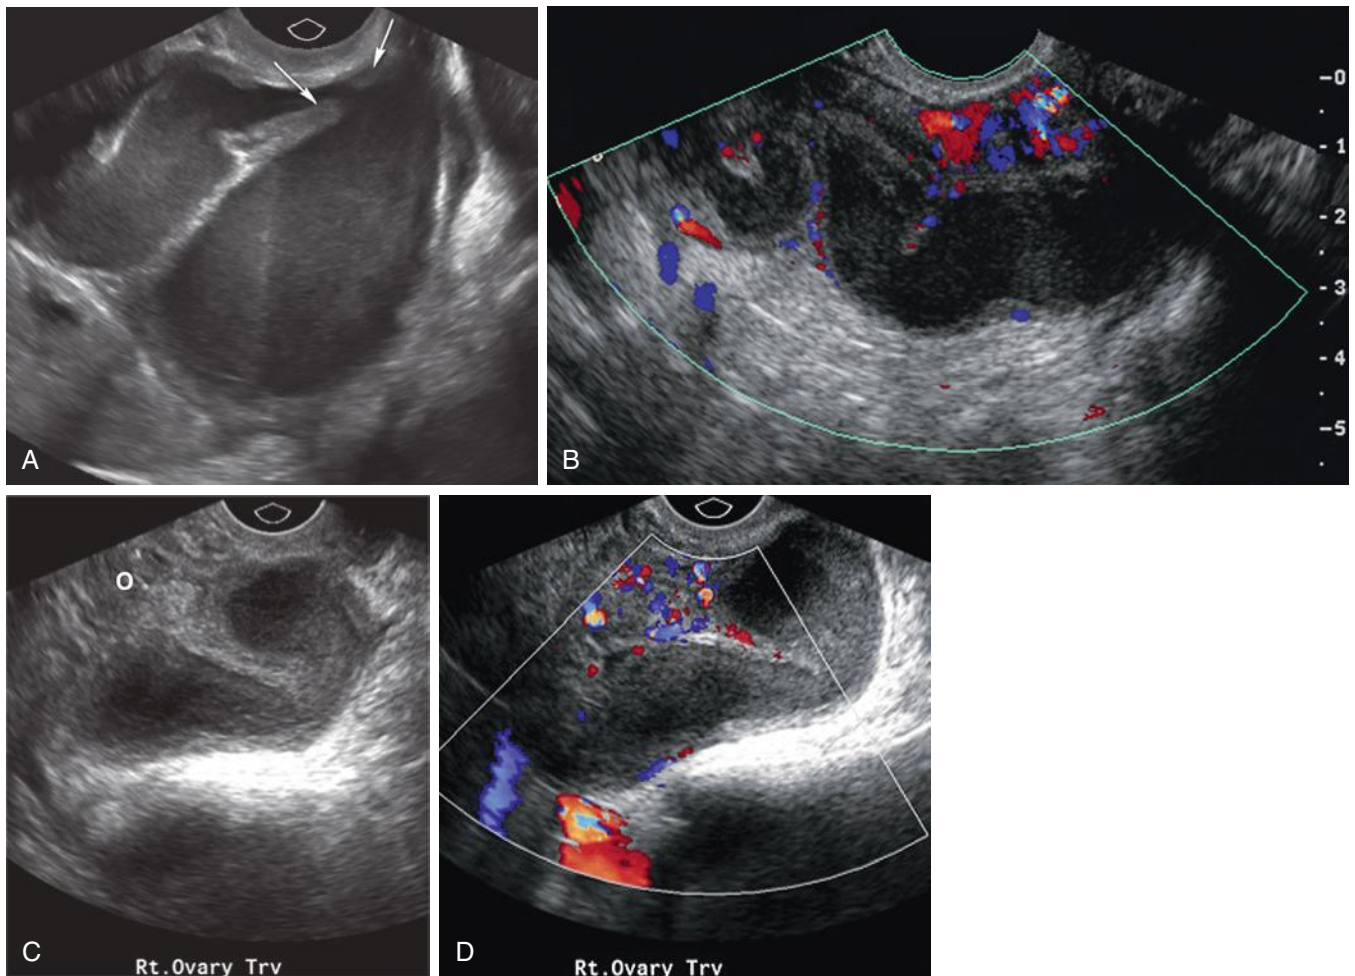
Pyosalpinx. A, The left fallopian tube in a patient with pyosalpinx is markedly dilated and filled with echogenic material, consistent with pus, hemorrhage, or debris. Note fluid/fluid level and thick echogenic wall. The tube is curled back upon itself demonstrating the incomplete septation sign and is also focally symmetrically indented, the "waist sign" (*arrows*). B, Color Doppler image of the left adnexa in a second patient with pyosalpinx demonstrating a dilated serpiginous tubular structure containing low level intraluminal echoes and increased mural vascularity. Gray-scale (C) and color Doppler (D) ultrasound images from a third patient with pyosalpinx demonstrating a dilated fallopian tube adherent to the enlarged, edematous right ovary (O). The wall of the tube is thick and hyperemic and the lumen contains internal echoes. Findings are most consistent with pyosalpinx, although hematosalpinx could also result in layering or conglomerate intraluminal echoes within a dilated fallopian tube. (C and D courtesy of Dr. Margarita Revzin, Yale University School of Medicine, New Haven, CT)
